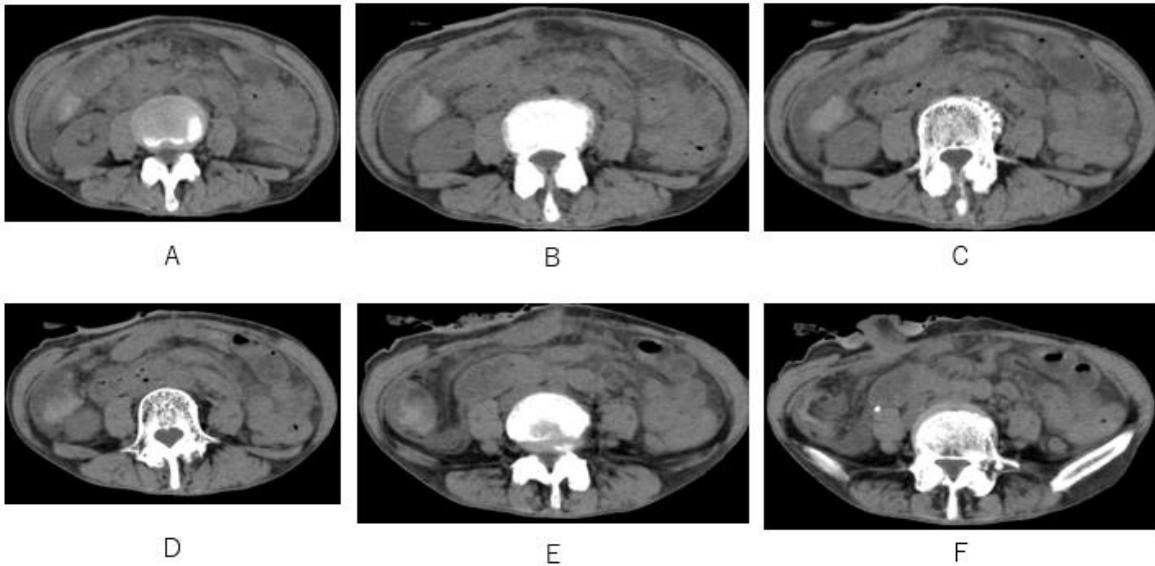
Fluids with high attenuation (CT values; around 60 HU) are depicted on axial CT.
